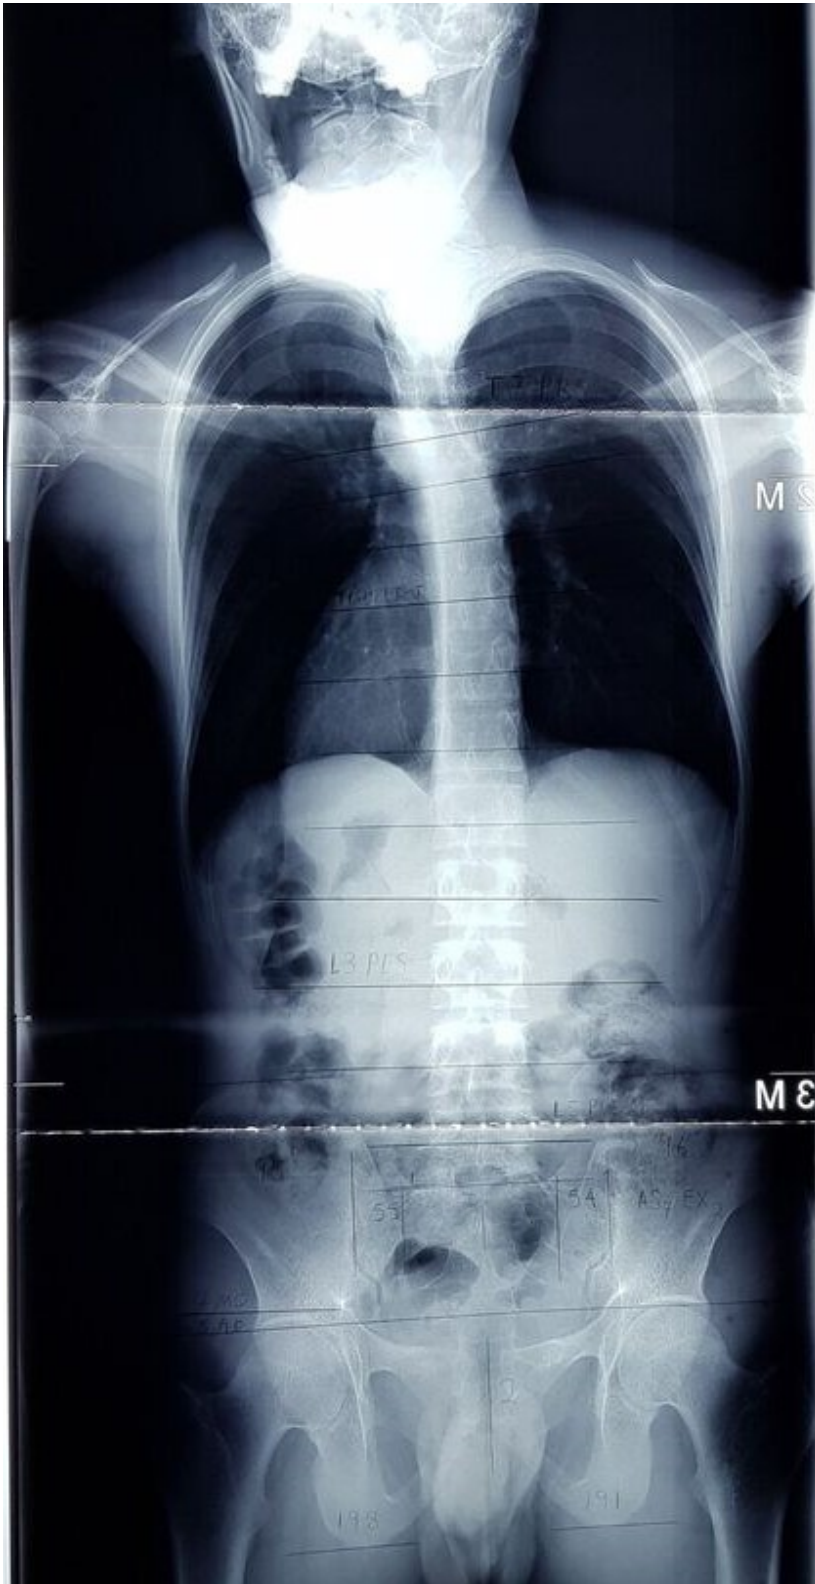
A-P View X-Ray taken prior to first adjustment
